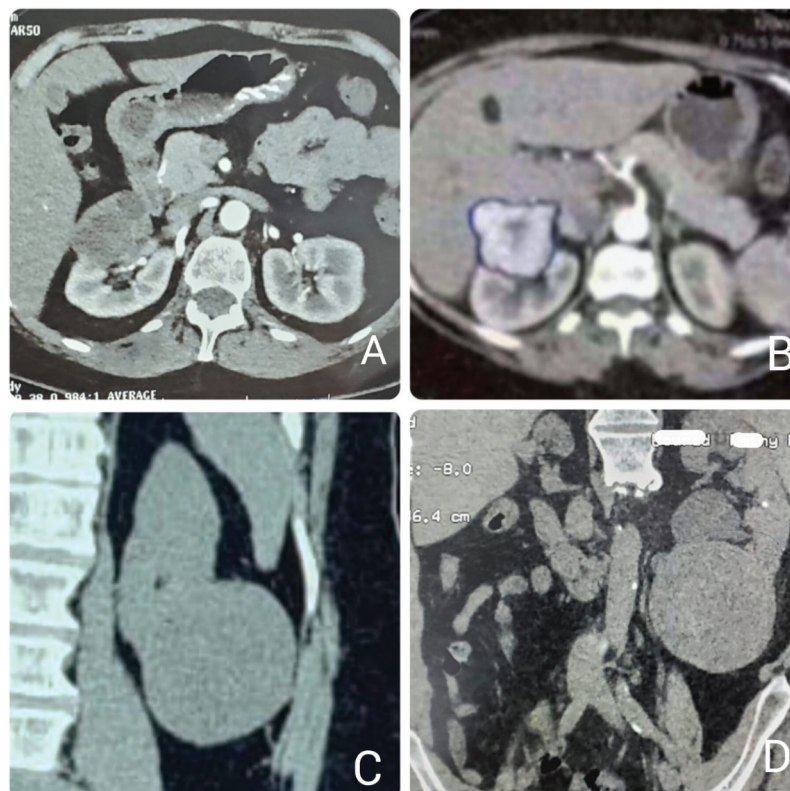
CT images for complex renal masses. A & B: Hilar tumors. C & D: Large lower polar mass.
